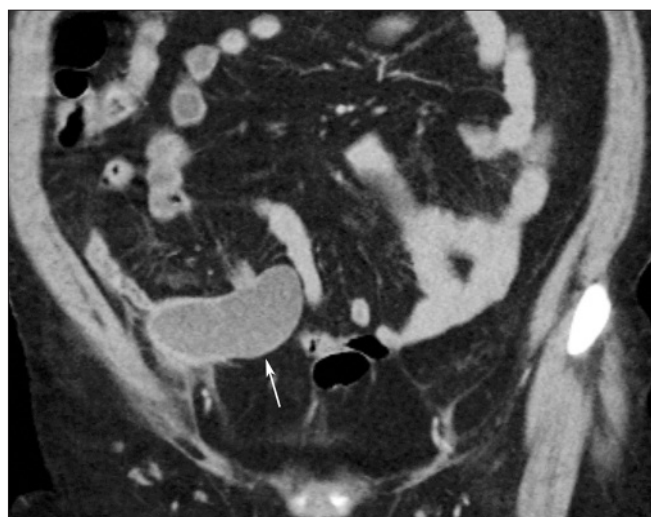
Contrast-enhanced (intravenous) coronal multiplanar reconstruction CT image shows a dilated cystic mass (arrow) in the expected region of the appendix
